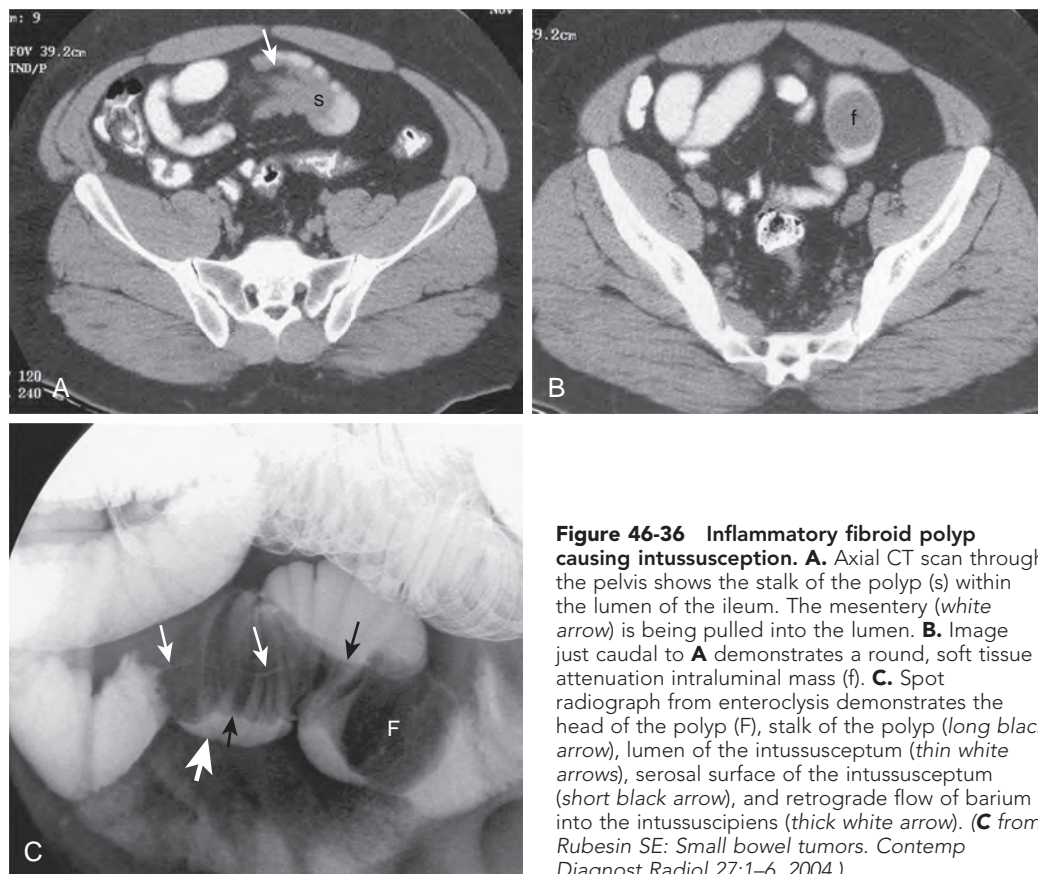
Inflammatory fibroid polyp causing intussusception. A. Axial CT scan through the pelvis shows the stalk of the polyp (s) within the lumen of the ileum. The mesentery (white arrow) is being pulled into the lumen. B. Image just caudal to A demonstrates a round, soft tissue attenuation intraluminal mass (f). C. Spot radiograph from enteroclysis demonstrates the head of the polyp (F), stalk of the polyp (long black arrow), lumen of the intussusceptum (thin white arrows), serosal surface of the intussusceptum (short black arrow), and retrograde flow of barium into the intussusciens (thick white arrow). (C from Rubesin SE: Small bowel tumors. *Contemp Diagnost Radiol* 27:1–6, 2004.)
